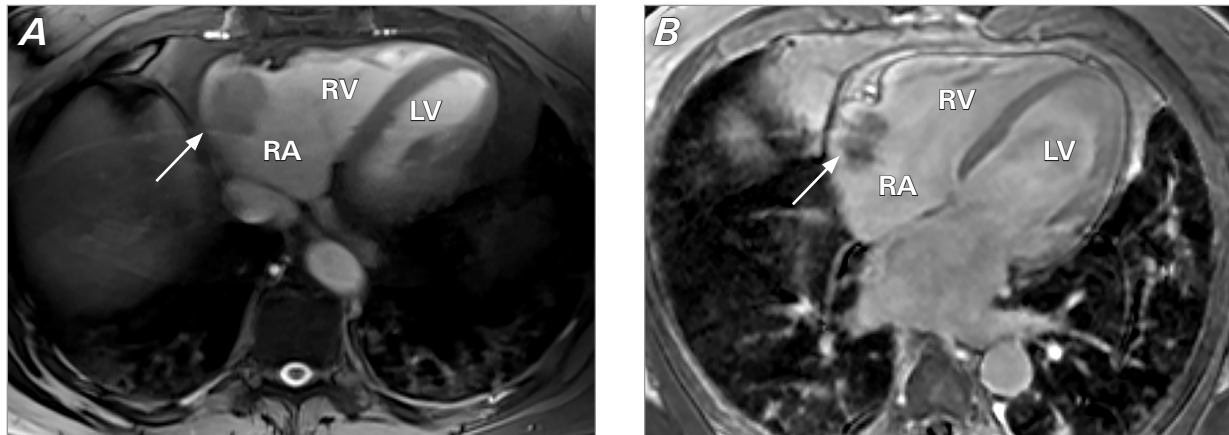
A) After discovery of the right atrial mass, cardiac magnetic resonance imaging with steady-state free precession protocol demonstrated the T1 hypointense lobulated mass measuring 4.1 × 2.7 cm (arrow) in the lower right atrium, attached to the anterior wall just above the tricuspid annulus and in the region of the Chiari network. B) The T2 slightly hyperintense lesion (arrow) was mobile and did not display late gadolinium enhancement and maintains low signal intensity on long inversion recovery sequences.
